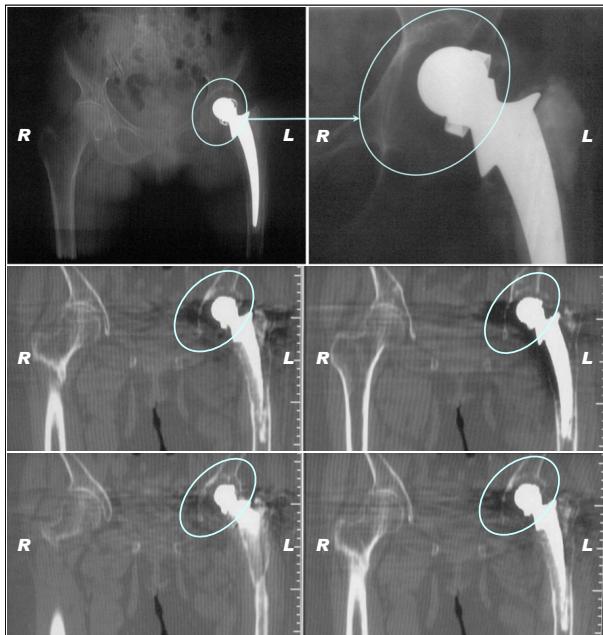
Standard X-rays before revision.
